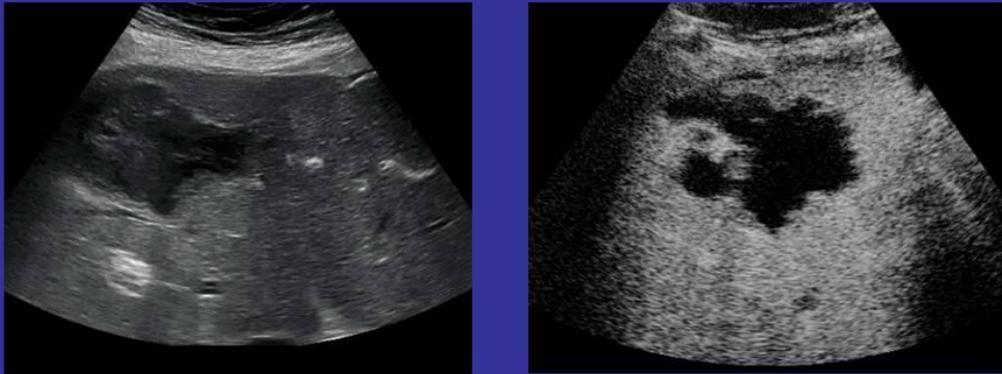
Abscess in a 75 years-old male patient. Baseline sonogram shows a poorly defined lesion with hypoechoic areas alternating with hyperechoic areas (Fig 5a). On CEUS imaging (Fig 5b), multiseptated pattern alternating with areas of no uptake were obtained, resulting in a type II pattern.
